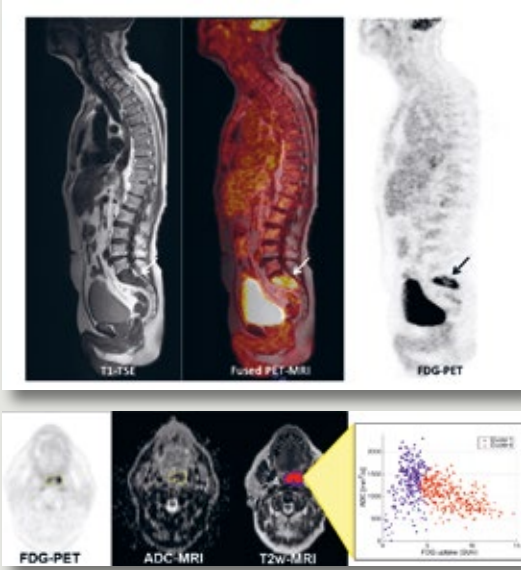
PET/MRI examination of a 72 year old male with a metastatic gastroesophageal junction cancer. The patient is scanned on a prototype flat table top in a project evaluating the use of PET/MRI in target definition in radiotherapy treatment of spinal metastases. Sagittal PET/MR images (from left, anatomic MRI (T1 TSE), fused PET/MRI and PET) show a metastatic transformed S1- and S2-segment (arrow) which affects both S1- and S2-nerve roots
